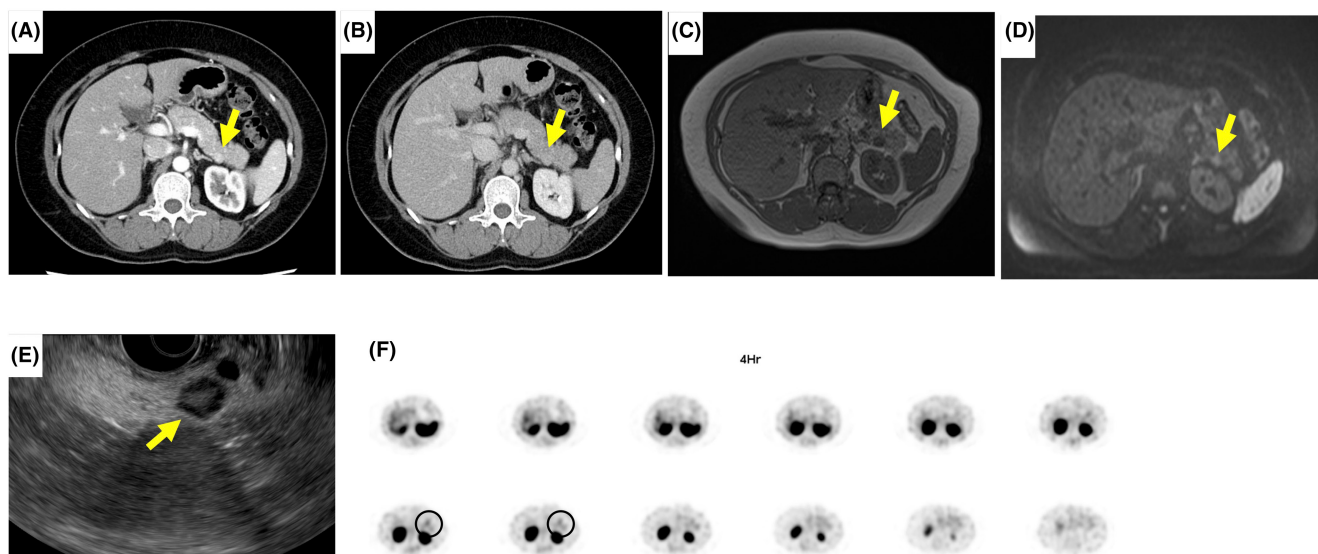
Imaging findings. Abdominal computed tomography (CT) with contrast showed an enhanced 9 mm nodule in the pancreatic tail on early image (arrow). (A) The lesion was isodense on delayed image (arrow). (B) Abdominal magnetic resonance imaging (MRI) revealed a nodule with a low signal on a T1-weighted image (arrow) (C) and a mildly high signal on a diffusion-weighted image (arrow) (D). Endoscopic ultrasound (EUS) showed a hypoechoic area (arrow). (E) Somatostatin scintigraphy showed mild uptake in the pancreatic tail (circle). (F).
